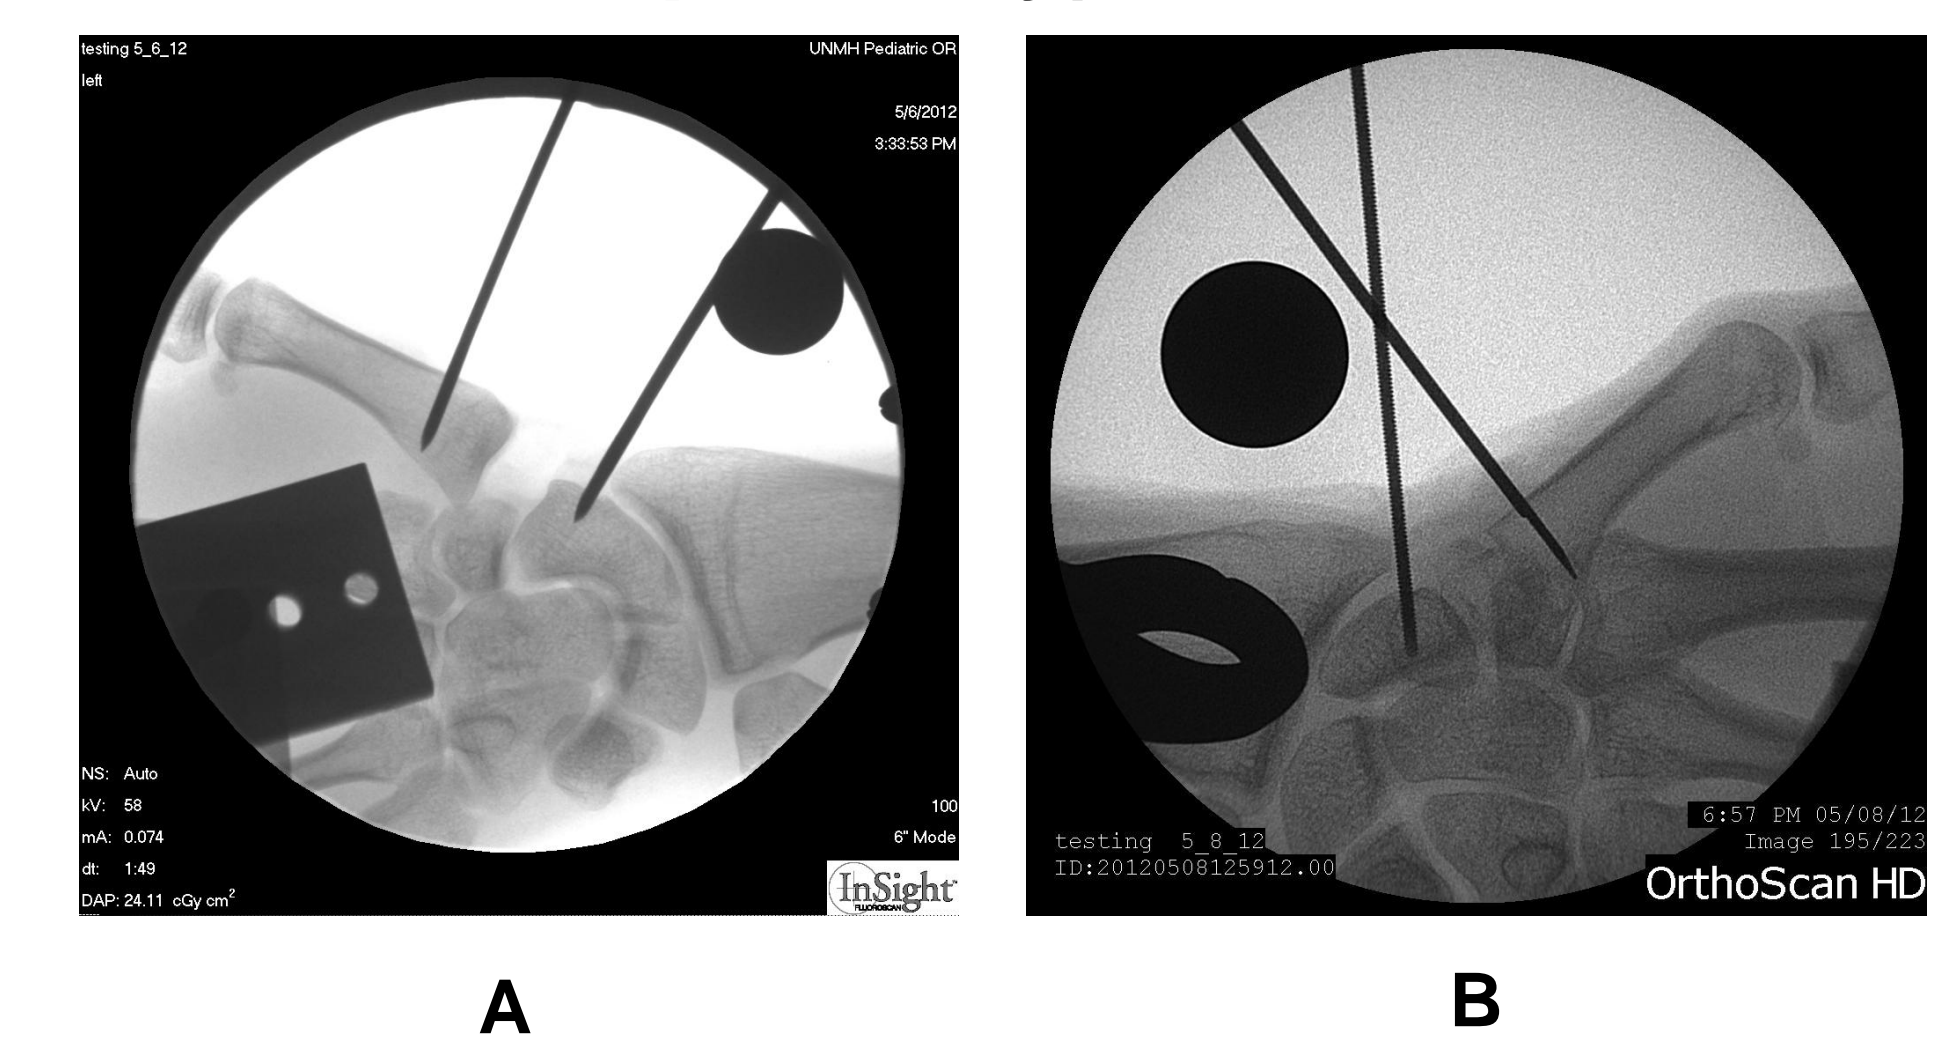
Antero-posterior radiographs showing K-wire placement in metacarpal and scaphoid bones plus spherical calibration marker after treatment with A. TRCI and B. PTCI.
